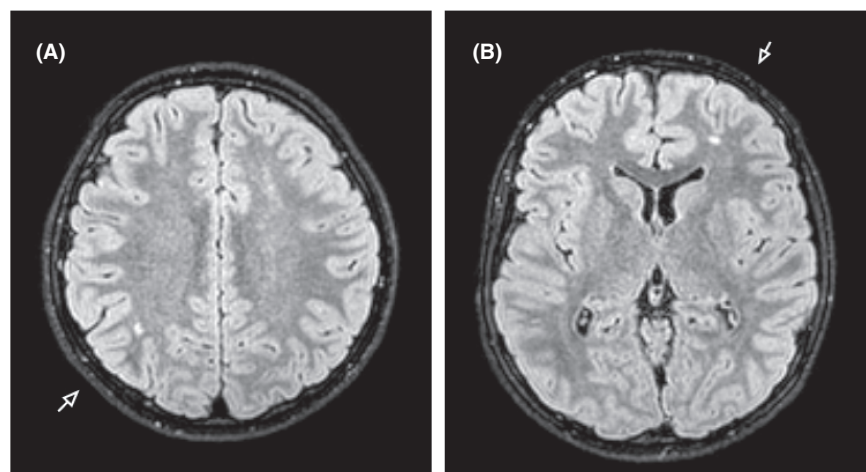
The brain MRI of a 13-year-old boy with paediatric panuveitis is shown. A, Axial FLAIR MRI with the arrows showing white matter abnormalities localized right parietal, and B, left frontal. These focal white matter abnormalities could be based on small focal areas of demyelination. Based on these white matter abnormalities, the patients deemed ineligible for treatment with adalimumab.
